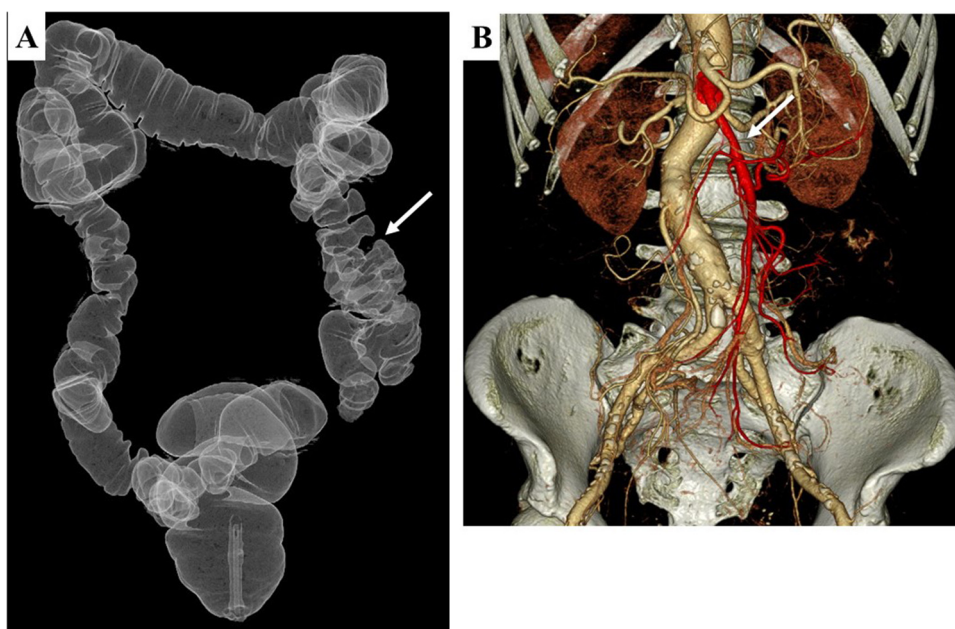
CT angiography and CT colonography. (A) Three-dimensional CT angiography shows the superior mesenteric artery, located on the right side (arrow). (B) CT-colonography shows a mass in the ascending colon.
